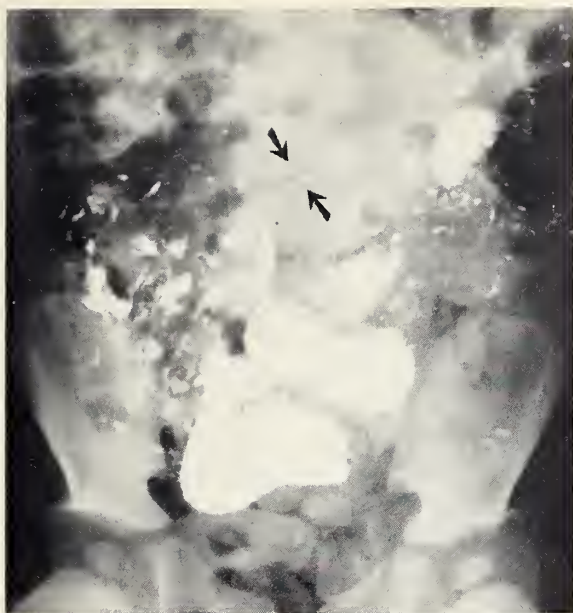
In the case of a three-year-old white boy who had no symptoms but passed *ascaris lumbricoides* per rectum, this x-ray film after barium meal shows a worm partially coated with barium.
